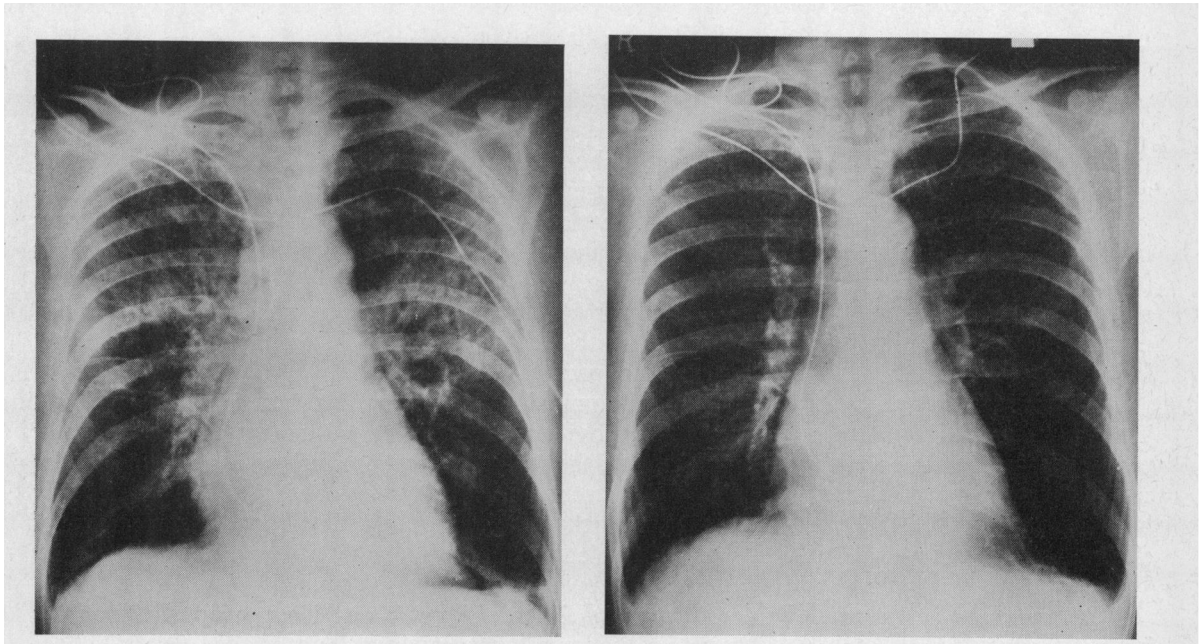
Chest radiographs before and after pacing, showing regression of pulmonary œdema and a decrease in heart size.
